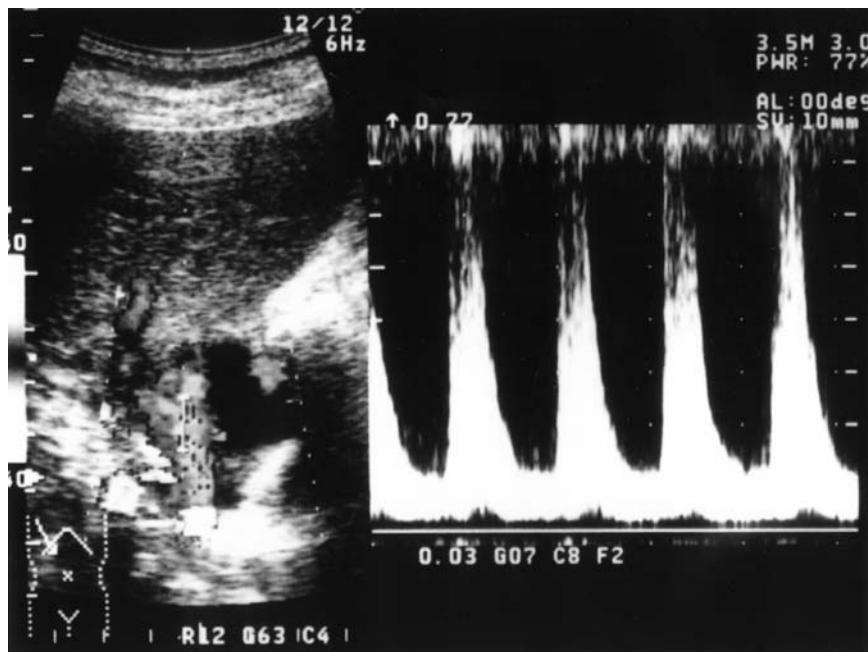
Color-Doppler ultrasound (US) imaging showed a pulsatile wave pattern in an echogenic lesion inside the gallbladder
